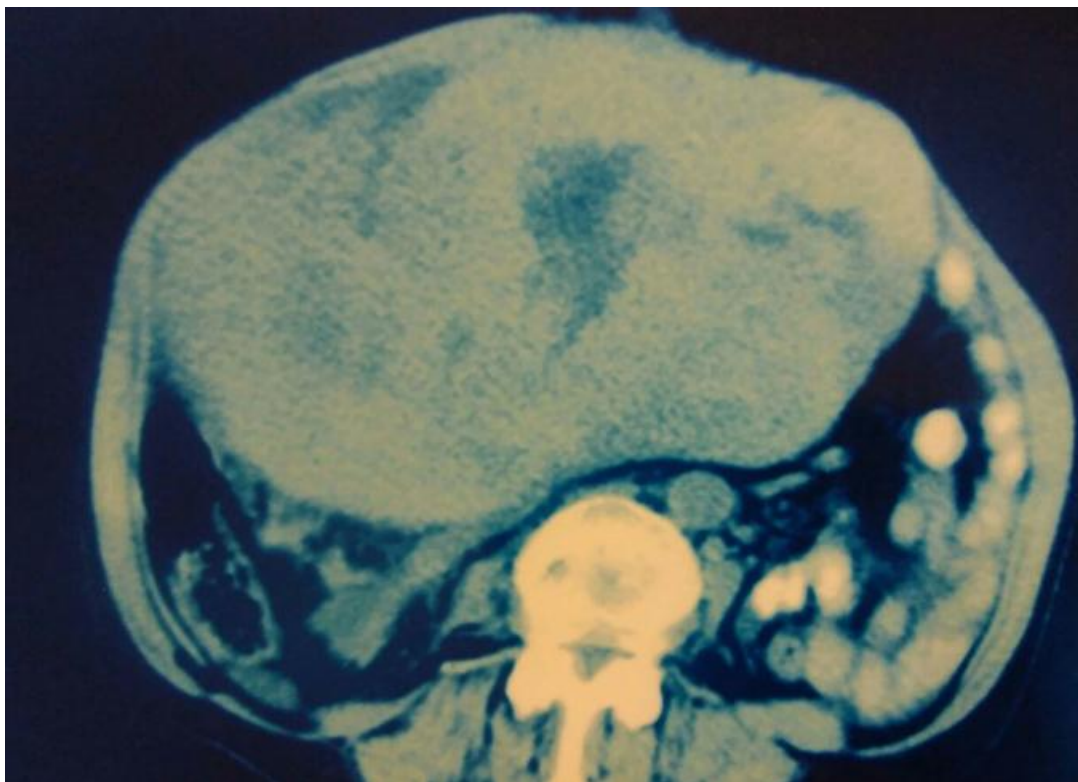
Abdominal CT scan showing a tissular polylobulated lesion occupying the entire abdomen cavity.
